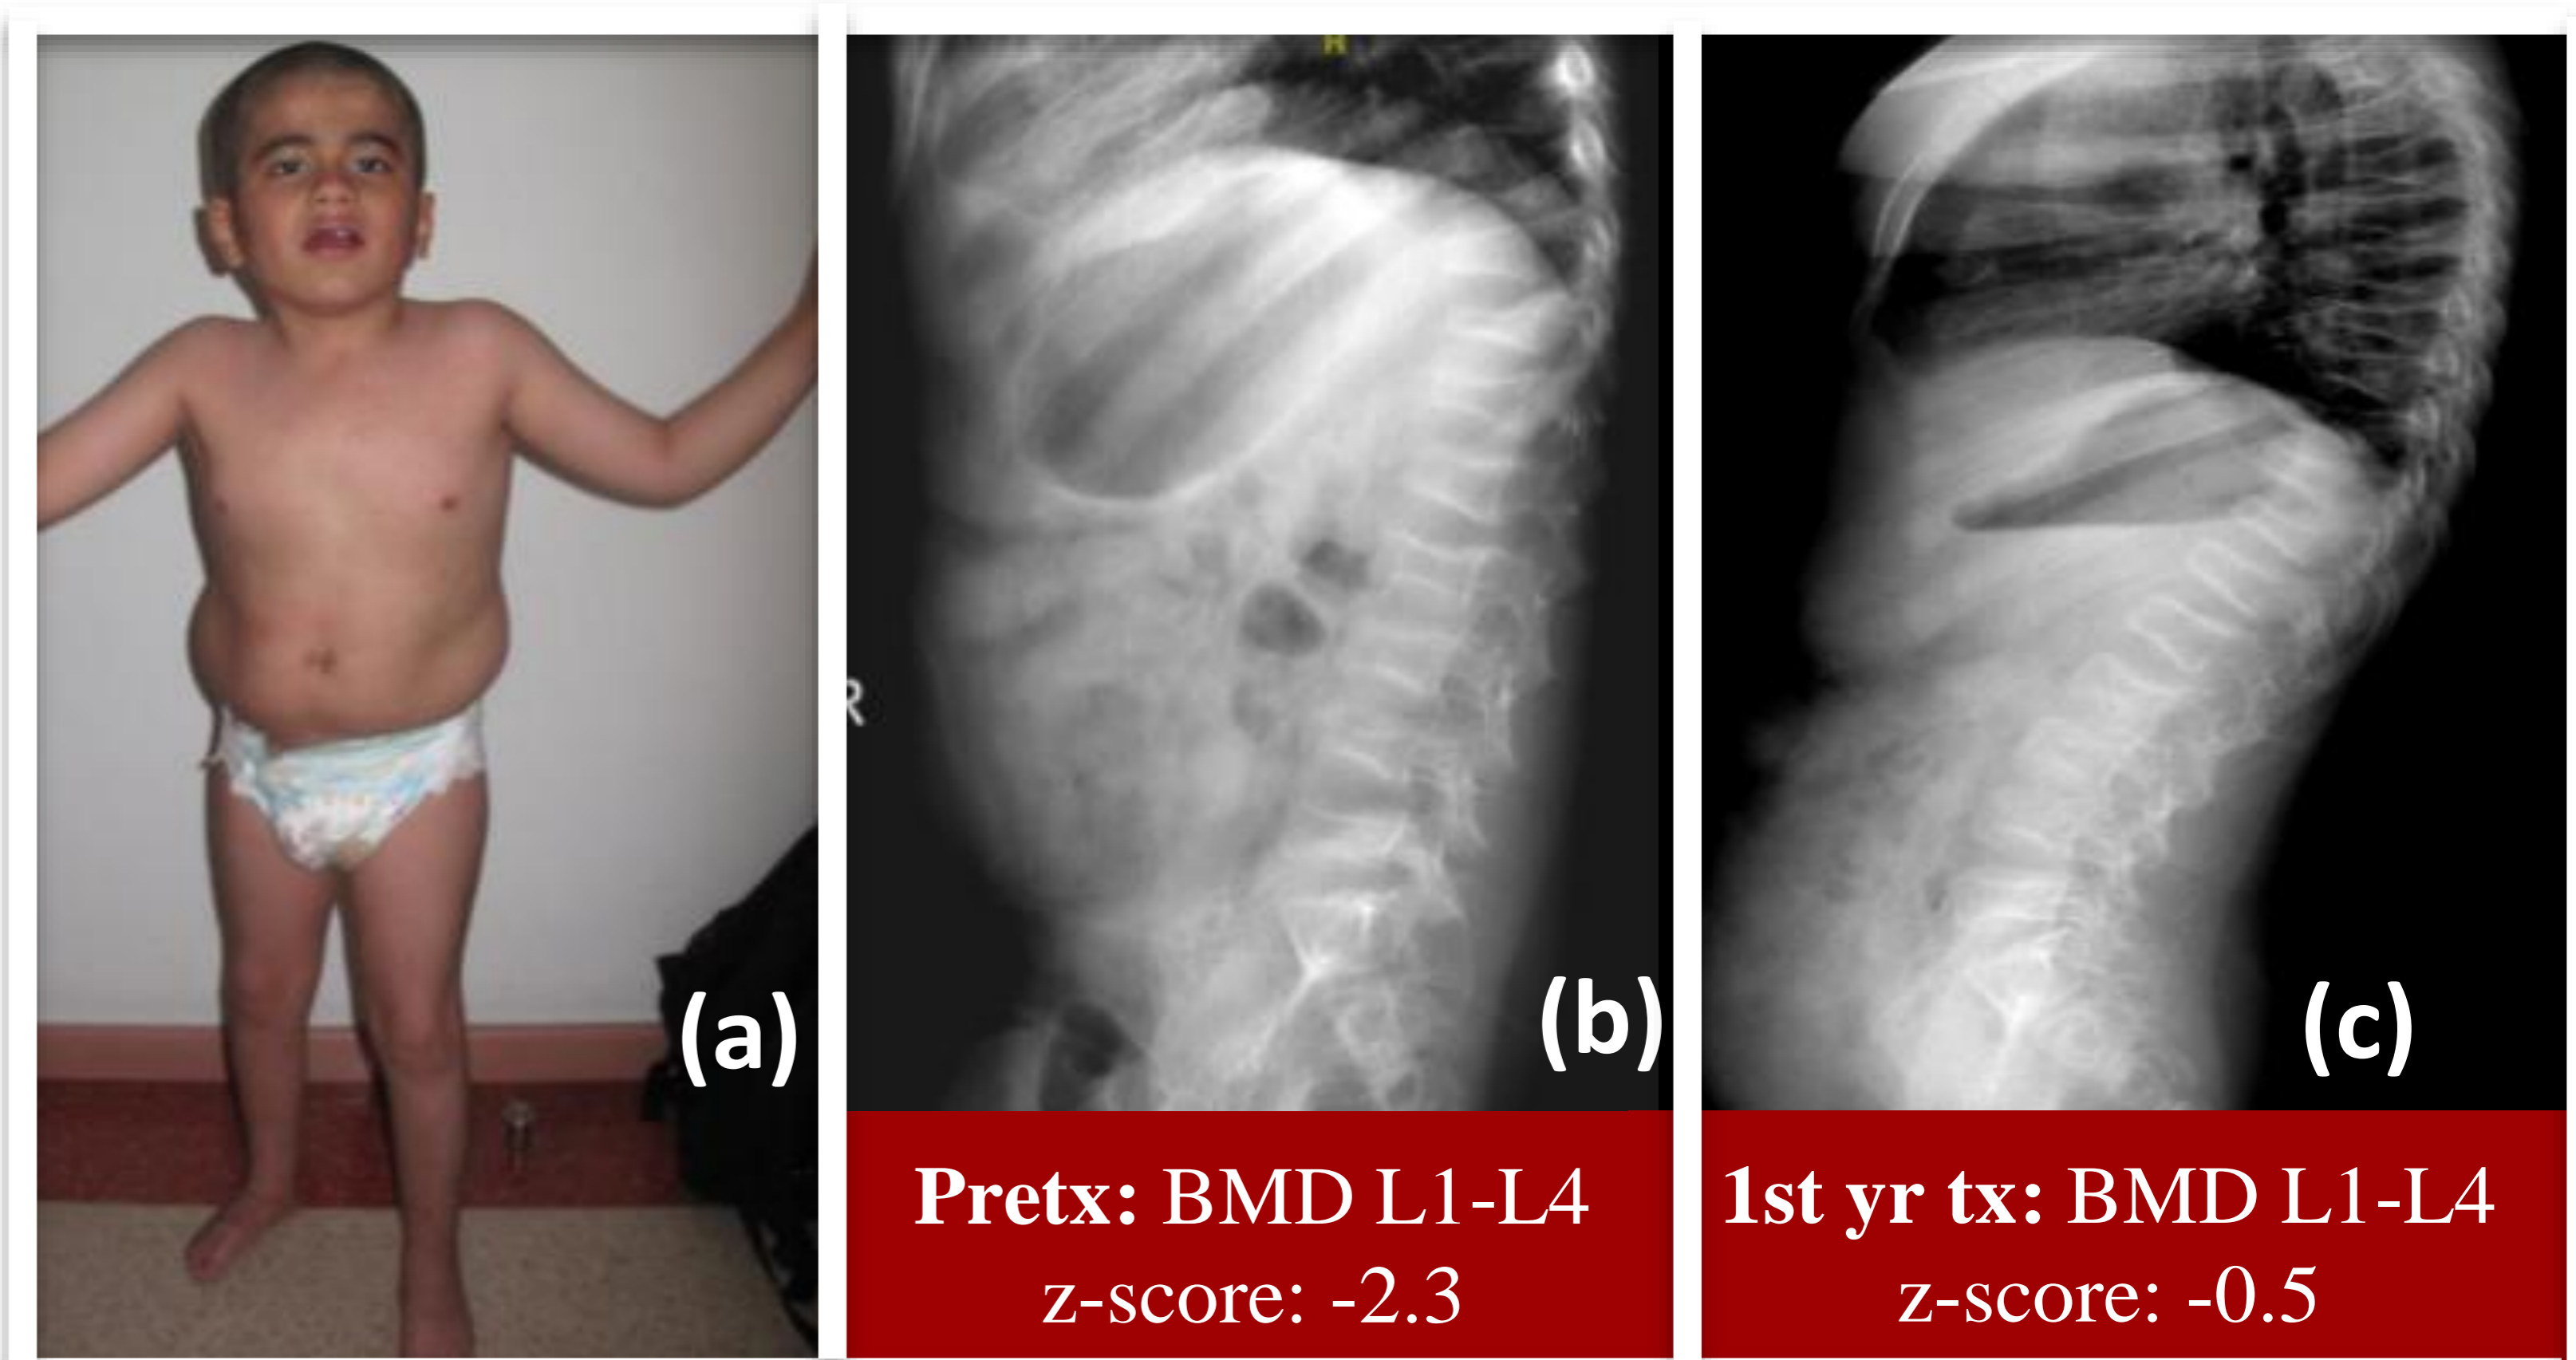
(a) Physical features of the patient's brother at admission, X-rays at (b) admission and (c) following the first year of bisphosphonate treatment.
